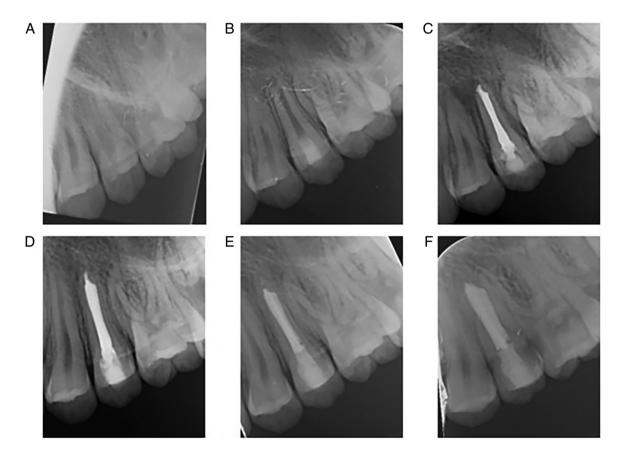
Follow-up periapical radiographs of tooth #25. (A) Preoperative radiograph. (B) 1-year follow-up radiograph after REPs; tooth #25 was treated by apexification with calcium hydroxide. (C) 1-year follow-up after conventional apexification, tooth #25 was subjected to conventional endodontic treatment. (D) 2-year, (E) 3-year and (F) 4-year follow-up after conventional apexification. REPs, regenerative endodontic procedures.
